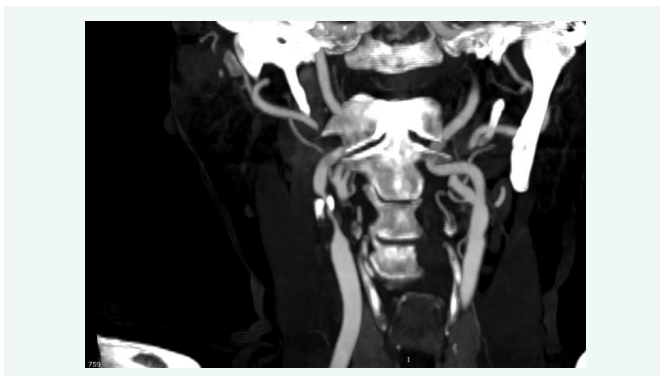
Coronal computed tomography angiography (CTA) demonstrating critical stenosis of the right internal carotid artery at the carotid bifurcation (arrow), with extensive circumferential calcification.
